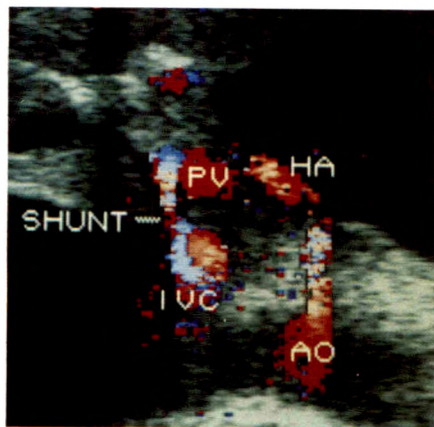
Patent portacaval shunt. Transverse subxiphoid sonogram. Shunt is seen as a direct vascular communication between portal vein (PV) and inferior vena cava (IVC). There is color flow aliasing in celiac artery, in which flow is color encoded white and light blue. This reflects both the zero Doppler angle and the rapid arterial flow rate. Local turbulence is seen in inferior vena cava at shunt insertion site. HA = hepatic artery, AO = aorta. (Reprinted with permission from Foley [2].)
